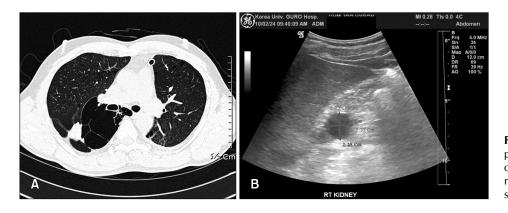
Imaging studies. (A) Multiple lung cysts found on chest computed tomography. (B) A right renal cyst found on abdominal sonography.
